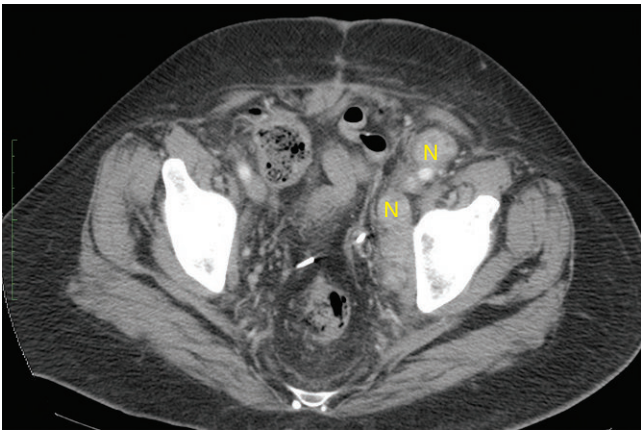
In the CT of the patient in [Figure S7-4](#), there is extrinsic compression on the iliac vein by metastatic adenopathy (N).
